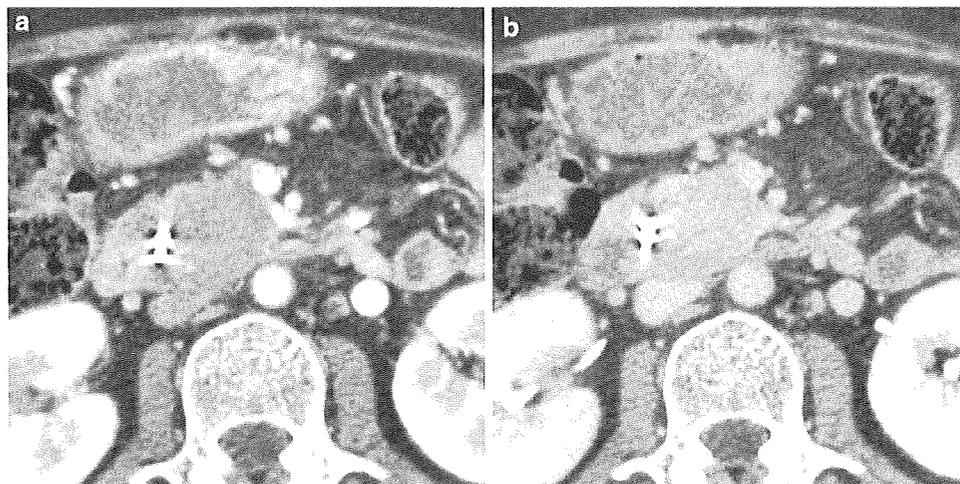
CT shows capsule-like rim and smooth margin in an AIP patient
